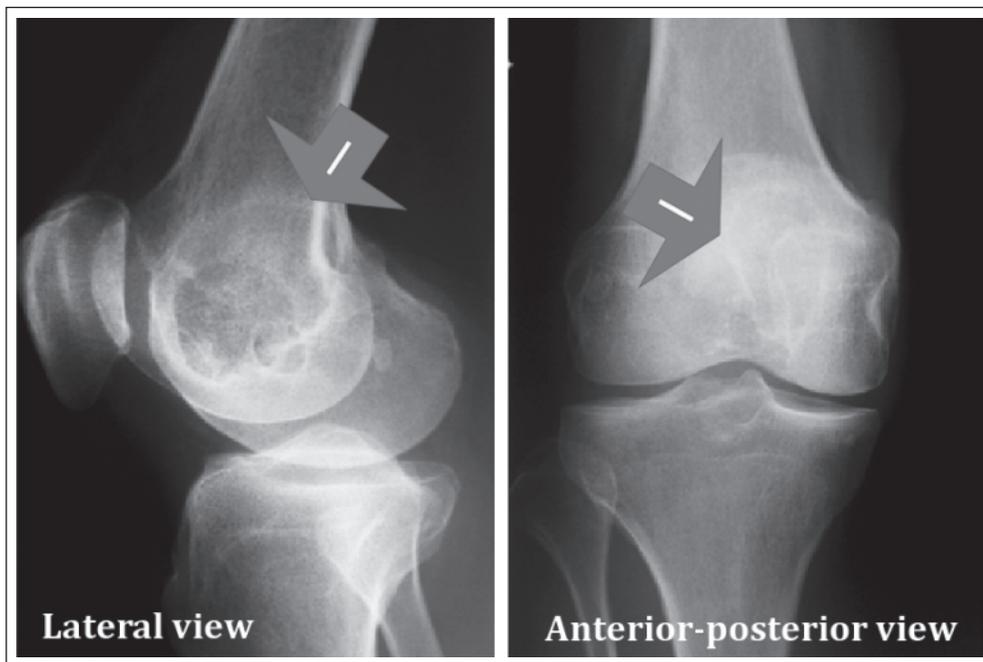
The radiograph of the distal femur osteolytic lesions
